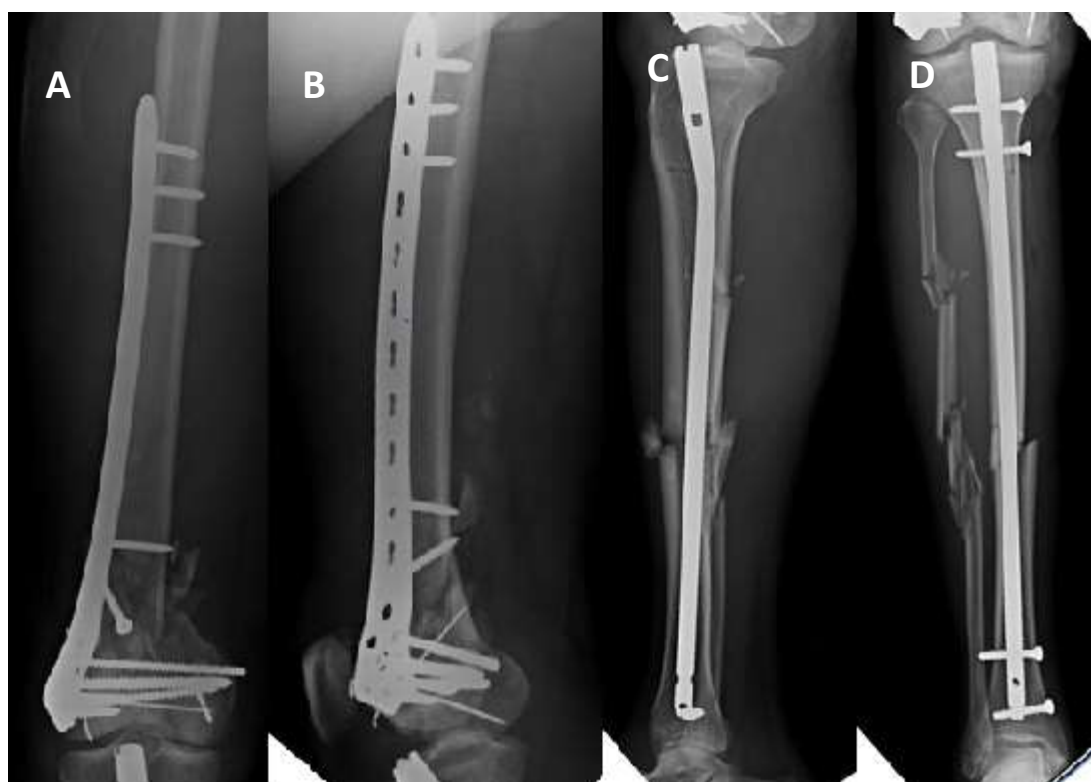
Post-operative radiograph showing; A: Antero-posterior view showing distal shaft femur fracture managed with lateral condylar buttressing plate and Kirschner wires; B: Lateral view showing distal shaft femur fracture; C: Lateral view showing mid-shaft tibia fracture managed with intra-medullary nail; D: Antero-posterior view showing mid-shaft tibia fracture managed with intra-medullary nail
